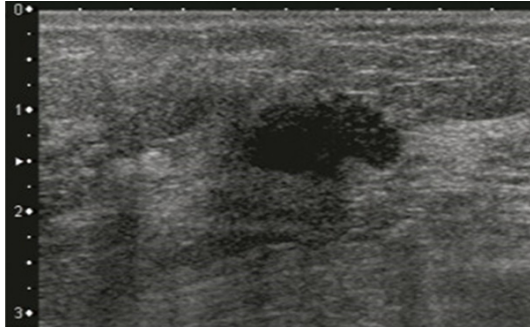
Ultrasonographic image. Ultrasonography revealed an irregular hypoechoic mass measuring 16 × 12 × 8 mm.
